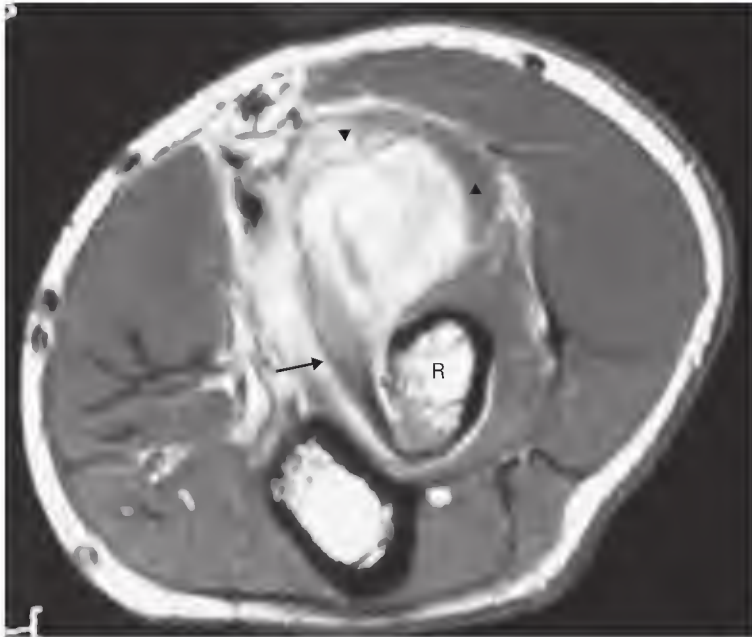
This patient was found to have a mass in her elbow. Axial T1-weighted magnetic resonance imaging with fat saturation after intravenous gadolinium enhancement demonstrates enhancing synovium in the bicipitoradial bursa (arrowheads) where the biceps tendon (arrow) inserts on the radius (R). Conventional radiographs of the hands demonstrated changes consistent with rheumatoid arthritis. This was the patient's initial findings.
